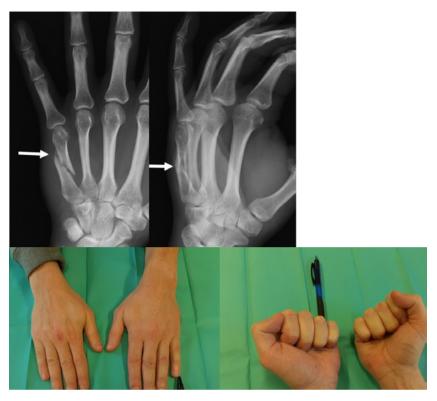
X-ray and range of motion of fingers in the patient 2 weeks after spiral fracture of the fifth metacarpal bone.
